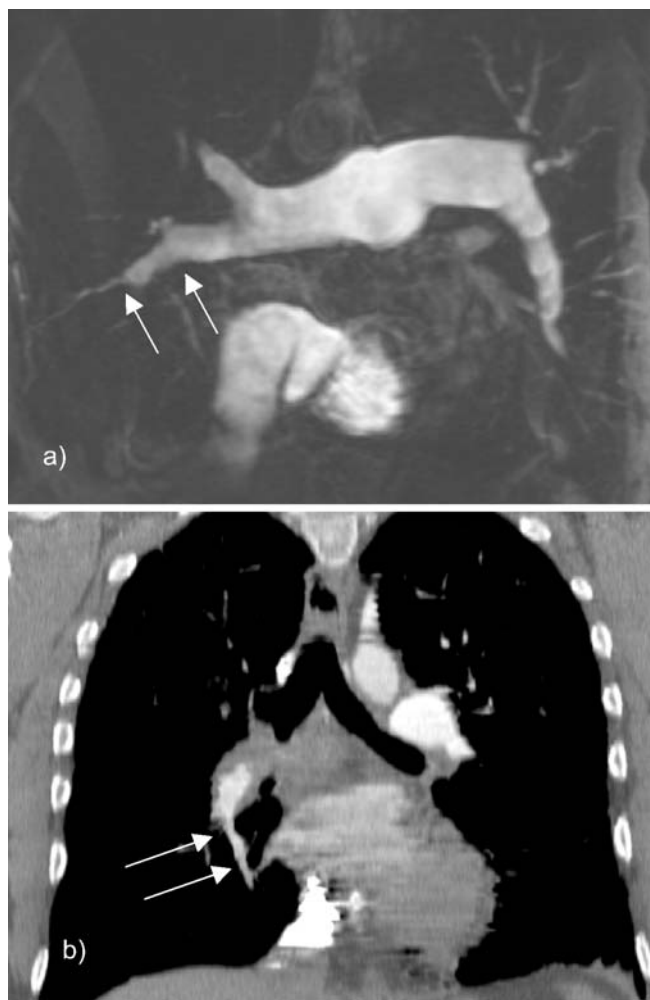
Demonstration of abnormal proximal to distal tapering in multiplanar reformation (MPR) mode from a MRA and b CTA (arrows)
